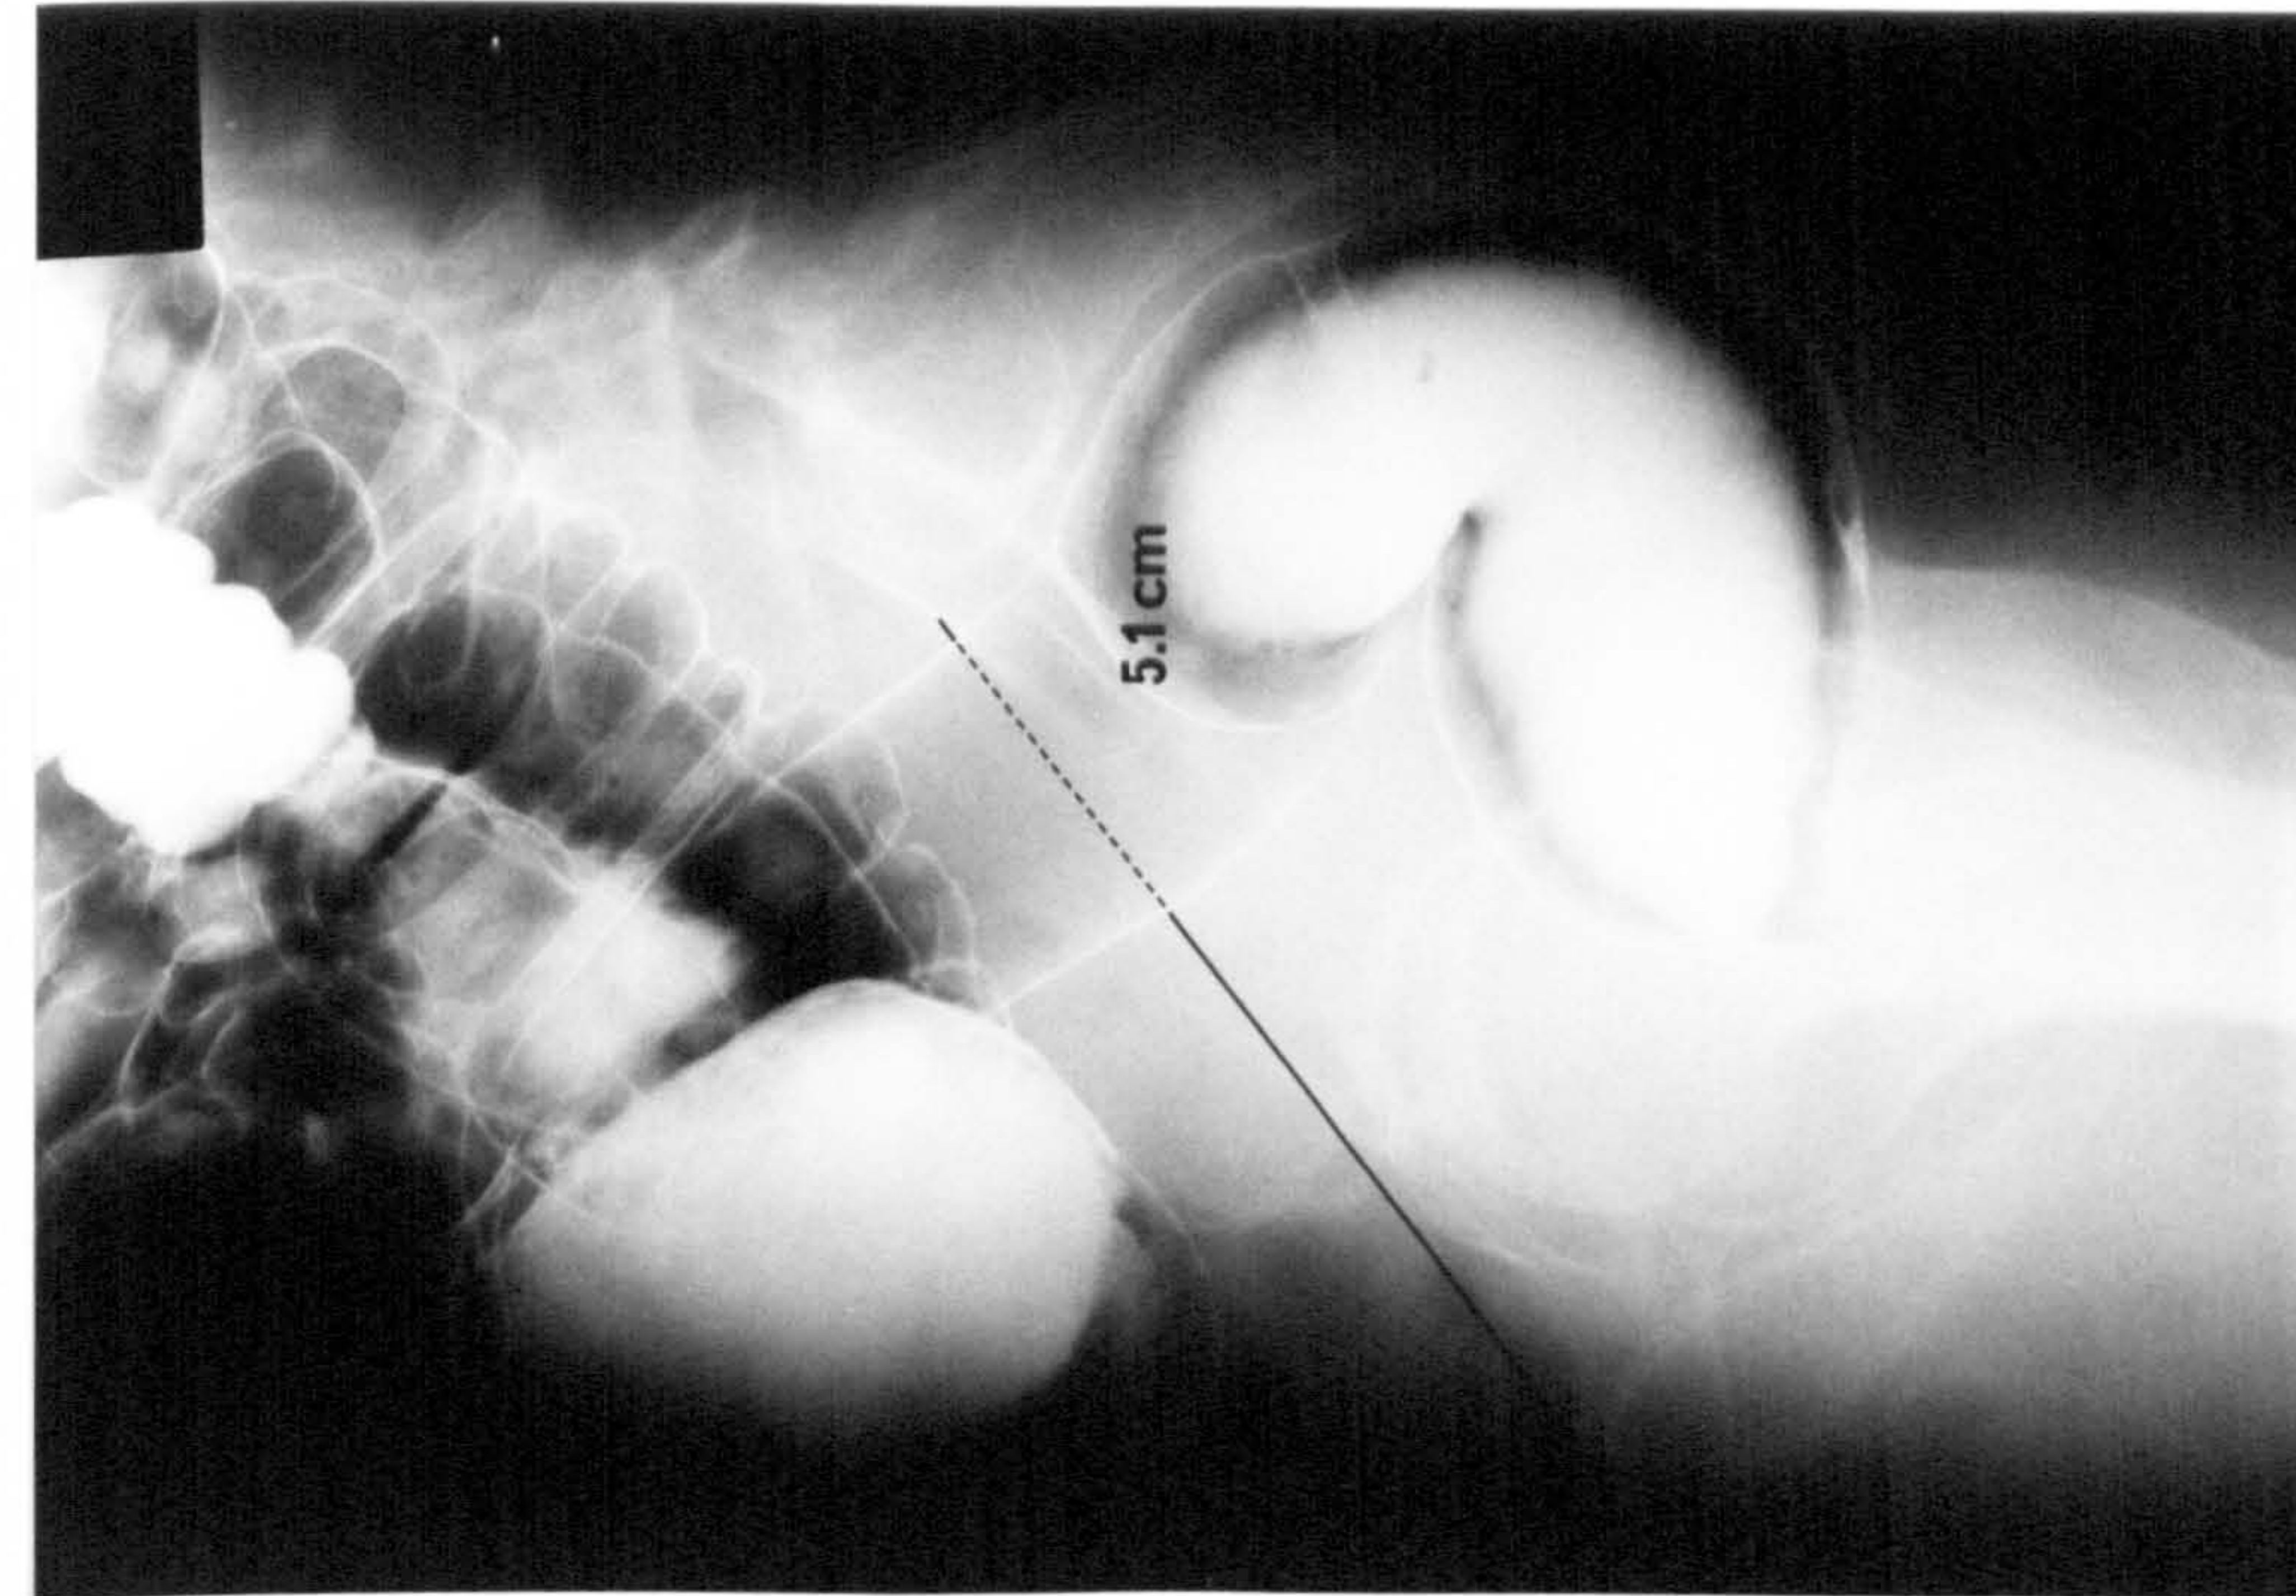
LATERAL PELVIC RADIOGRAPH TAKEN FROM A NORMAL SUBJECT. The level of the pelvic brim is indicated by a line joining the top of the pubis and the upper border of the body of the second sacral vertebra
